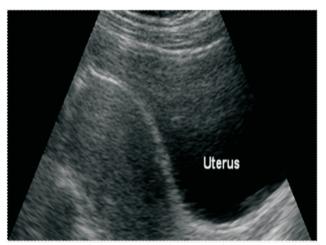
Ultrasound showed Normal contour of the uterus with the cervix not being visualized
